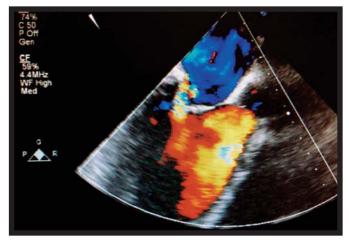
Postoperative echocardiographic view
